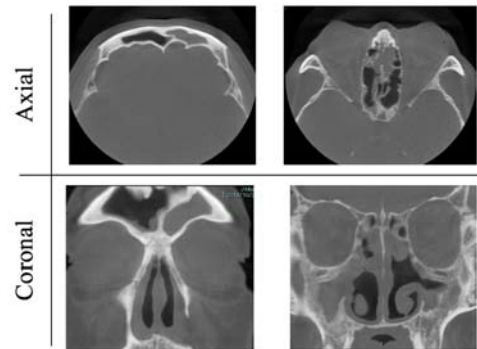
CT images of a patient who suffers
